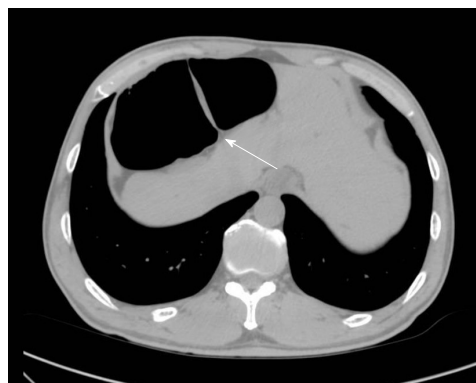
Computed tomography findings. Computed tomography shows an interposition of the colon hepatic flexure between the liver and the right diaphragm.
